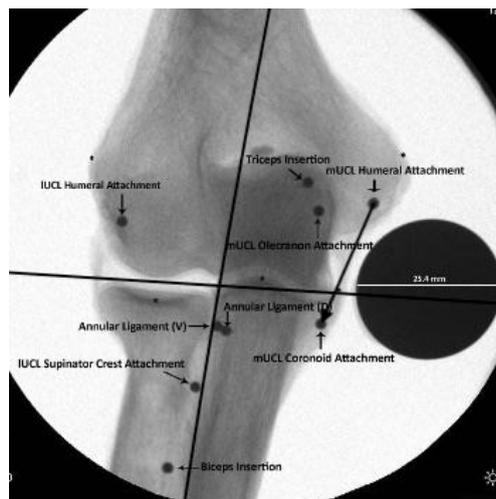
AP radiograph image demonstrating example measurement. The lateral ulnar line and a line parallel to the joint are present. Asterisks denote osseous landmarks: medial epicondyle, lateral epicondyle, coronoid tip, the center of the radial head, and medial margin of the coronoid process. D: dorsal attachment; V: volar attachment; MUCL: medial ulnar collateral ligament; LUCL: lateral ulnar collateral ligament
